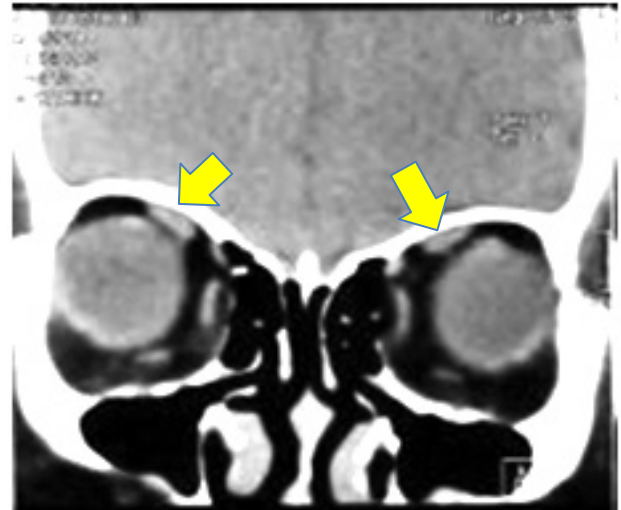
Orbital CT-scan revealed medial displacement of SR (yellow/upper row arrows) of both eye
